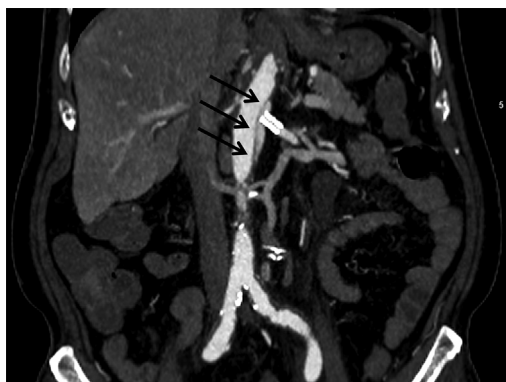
Renal artery CT angiography and renal artery angiography. (A) Renal artery CT angiogram shows severe stenosis of the left main renal artery origin site (90%; arrows). (B) Conventional angiogram of the renal artery demonstrates left renal artery stenosis (arrows). (C) A stent was successfully inserted into the left renal artery. After angioplasty and stent insertion, blood flow to the left renal artery was markedly improved. However, focal aortic dissection (arrows) developed right after the intervention. CT, computed tomography.
